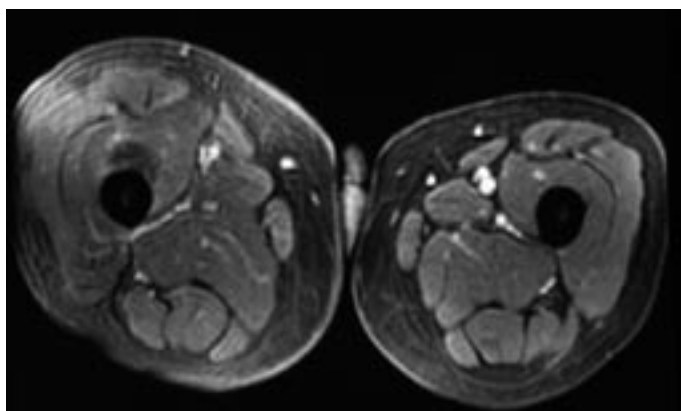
T2-weighted fat suppression image of left and right thigh. Notice the diffuse inflammation in the anterior compartment of the right thigh.
